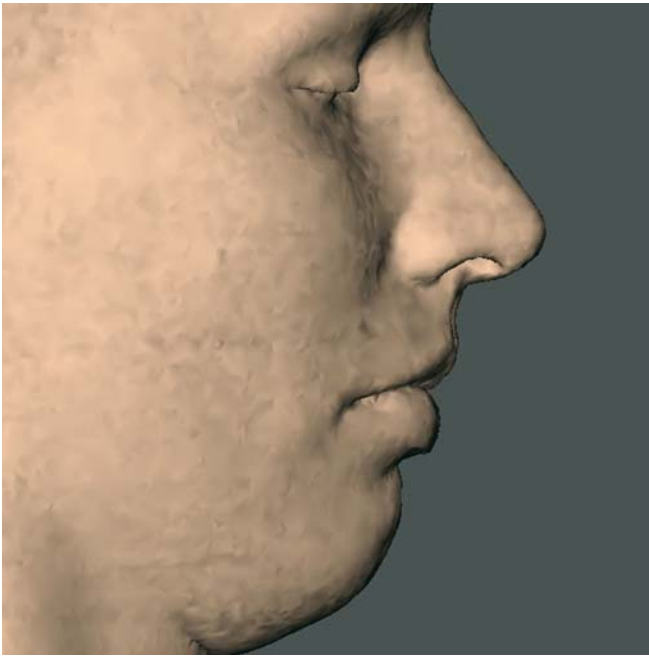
Subspinale. Profile view right (3-D CT, patient K.C.)
